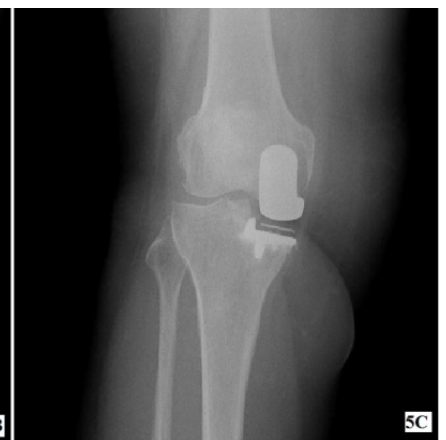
Early postoperative anterior posterior roentgenogram after arthroscopic procedure
